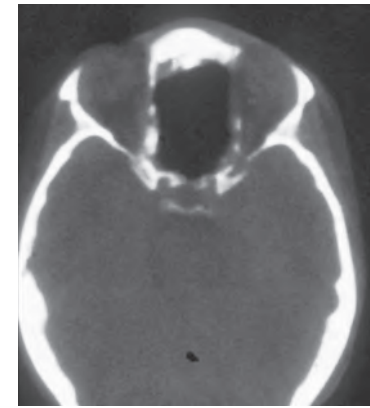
Axial computed tomography scans show a hypodense fibroosseous lesion of the ethmoid sinuses.
